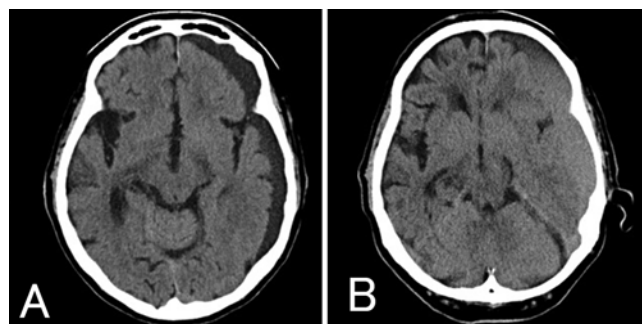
CT images of a patient with CSDH treated with observation only. A: Day 1. B: At 1 month.
